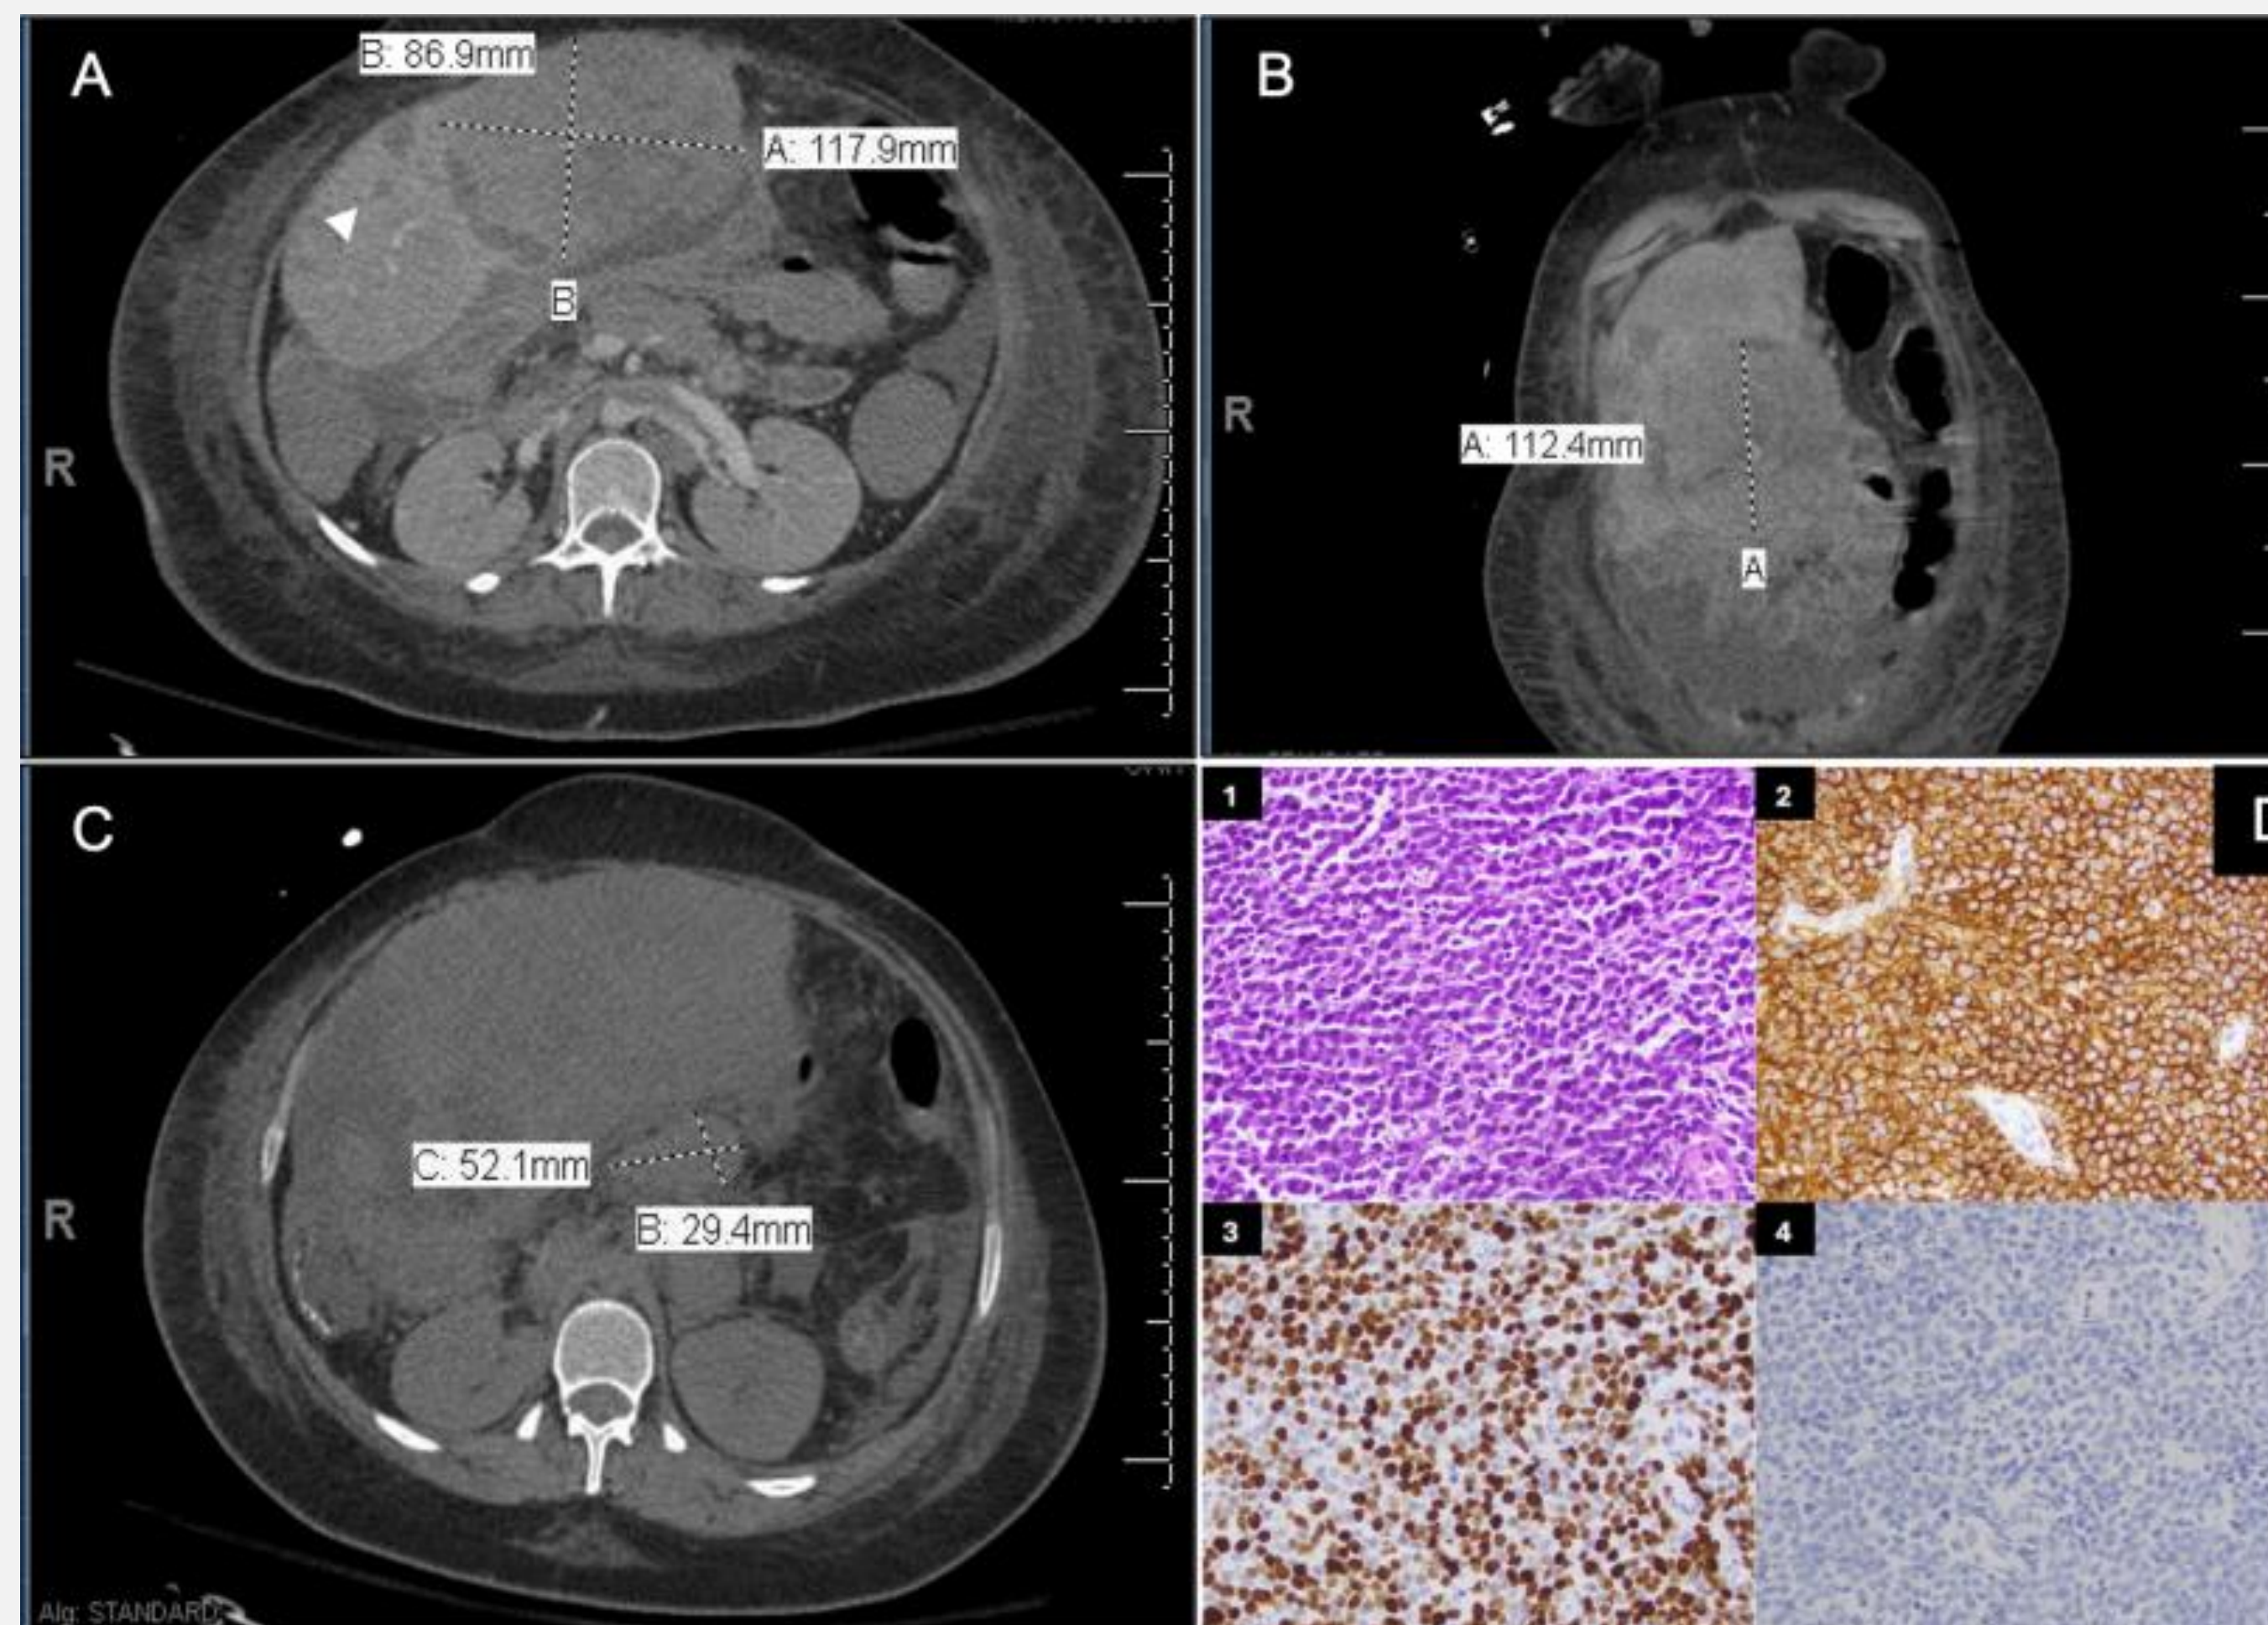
Non-contrasted CT Imaging and Pathology Findings
